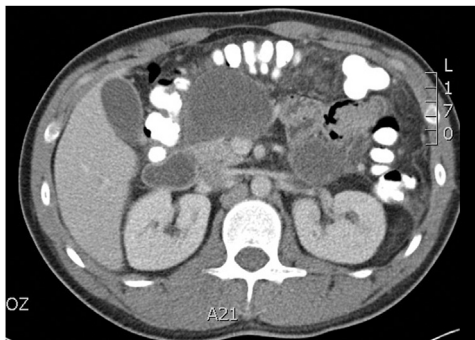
Enhanced CT scan with central walled-off pancreatic necrosis unamenable to left retroperitoneal percutaneous approach.
